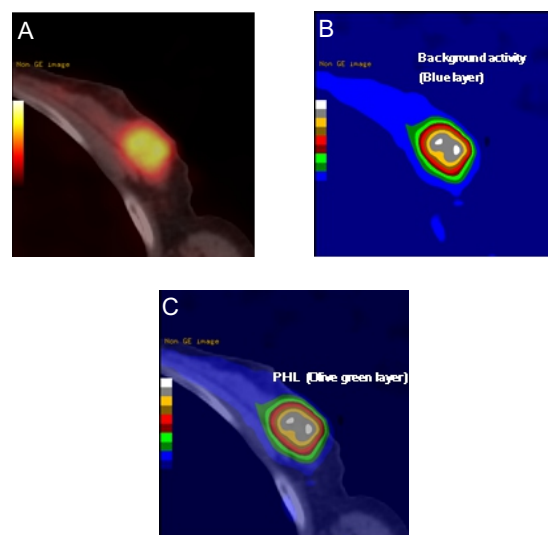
Example of PHL determination and measurement of tumor size on ^{18}F -FDG PET/CT. A. (PET/CT image), B. (PET image using 10-step color scale with SUV max adjustment), C. (fused PET/CT image using 10-step color scale). SUVmax of breast cancer is calculated by placing a spherical volume of interest over the tumor (A). The color map of PET is then changed to a 10-step color scale, which is calibrated by tumor SUVmax (dark blue layer=0-10% of tumor SUVmax, white layer= ~90% of tumor SUVmax). Peri-tumoral halo layer (PHL) is defined as an abrupt increase in layer thickness, apart from background activity (physiologic breast uptake, blue color). In this example, PHL is the olive-green layer (20%-30% of tumor SUVmax) and the tumor boundary is the inner margin of the PHL (30% of tumor SUVmax) (B, C).
